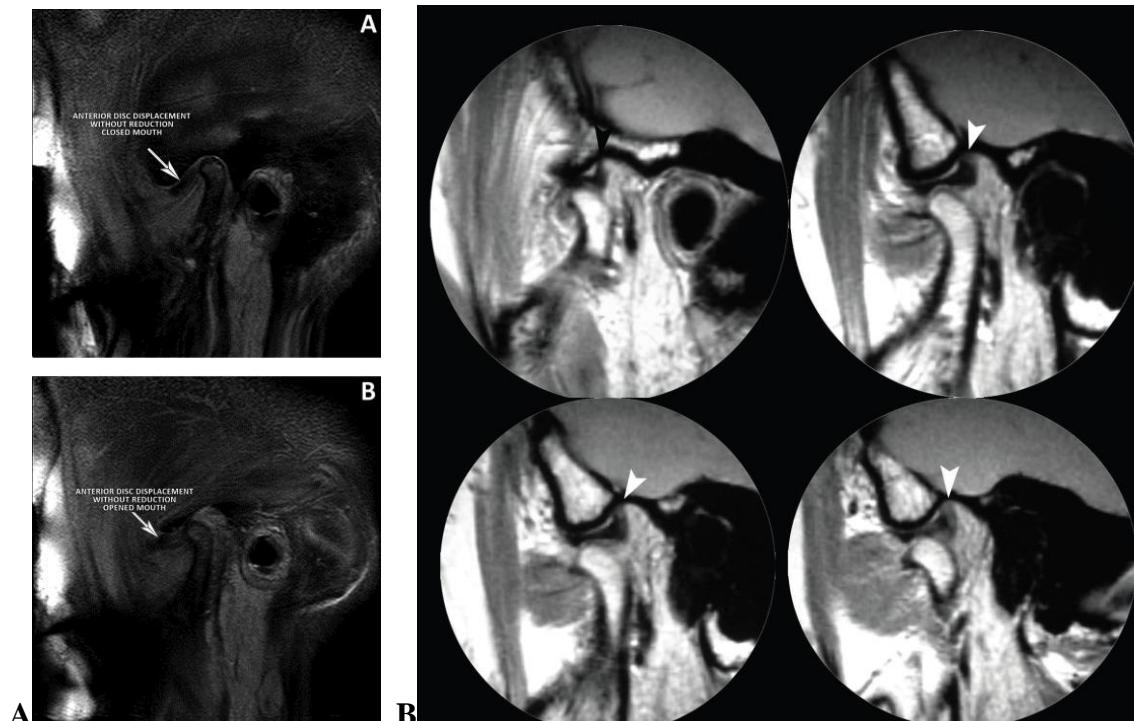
MRI sagittal views of anteriorly displaced disc and normally positioned adhered disc. (A) Anterior DDwoR on closed and opened mouth positions. (B) ADP during mouth opening movement. The images show: condylar hypomobility, normally positioned disc with limited mobility, and apparent fibrous adhesion band between the posterior band of the disc and the glenoid fossa (arrows). Reproduced from Galhardo *et al.* (2013) and de Melo *et al.* (2014) with permissions from Elsevier and Revista Gaúcha de Odontologia (RGO) respectively.
